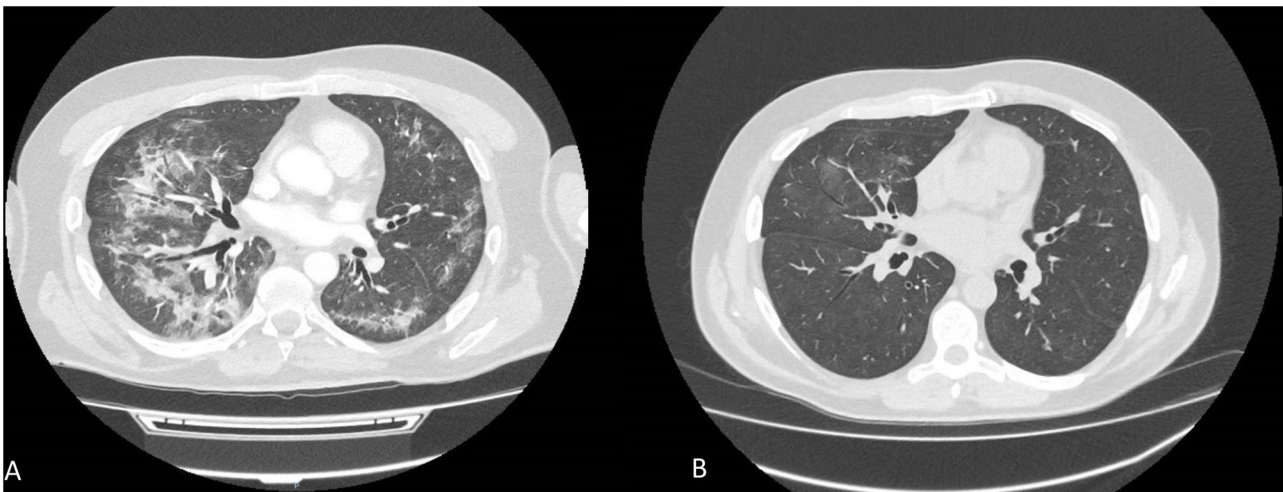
Patient 1. (A) CT scan shows subpleural parenchymal bands, ground-glass opacities and bilateral consolidations in both lung fields at 3 months after started apalutamide. (B) CT scan at 3 months after discontinuing apalutamide, showed a significant improvement with resolution of previously described pulmonary signs.
